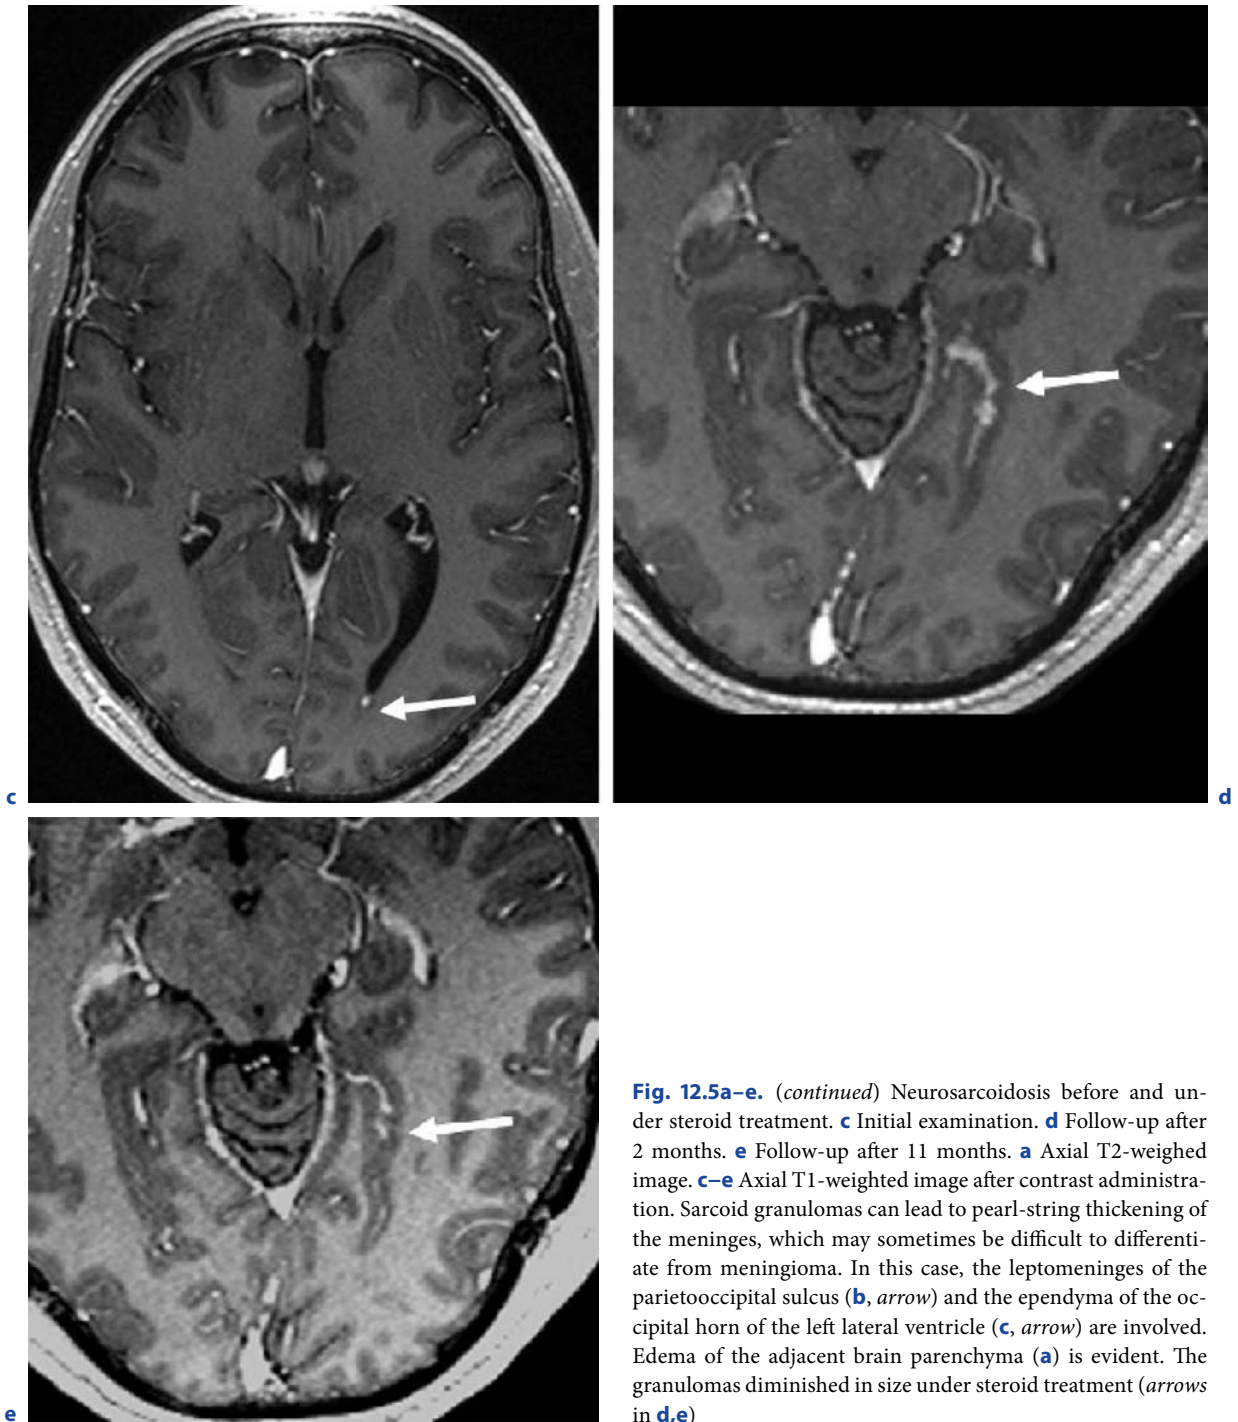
(*continued*) Neurosarcoidosis before and under steroid treatment. c Initial examination. d Follow-up after 2 months. e Follow-up after 11 months. a Axial T2-weighted image. c–e Axial T1-weighted image after contrast administration. Sarcoid granulomas can lead to pearl-string thickening of the meninges, which may sometimes be difficult to differentiate from meningioma. In this case, the leptomeninges of the parietooccipital sulcus (b, *arrow*) and the ependyma of the occipital horn of the left lateral ventricle (c, *arrow*) are involved. Edema of the adjacent brain parenchyma (a) is evident. The granulomas diminished in size under steroid treatment (*arrows* in d,e)
